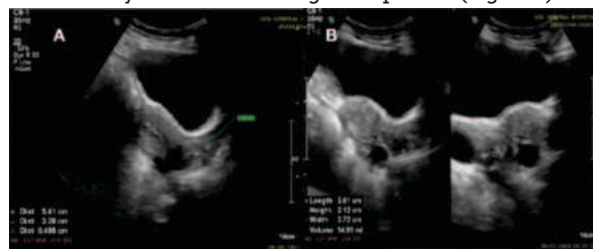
Sagittal(A) and axial sections (B) of ultrasound pelvis showing normal uterine endometrium and simple cysts in ovaries (B).
